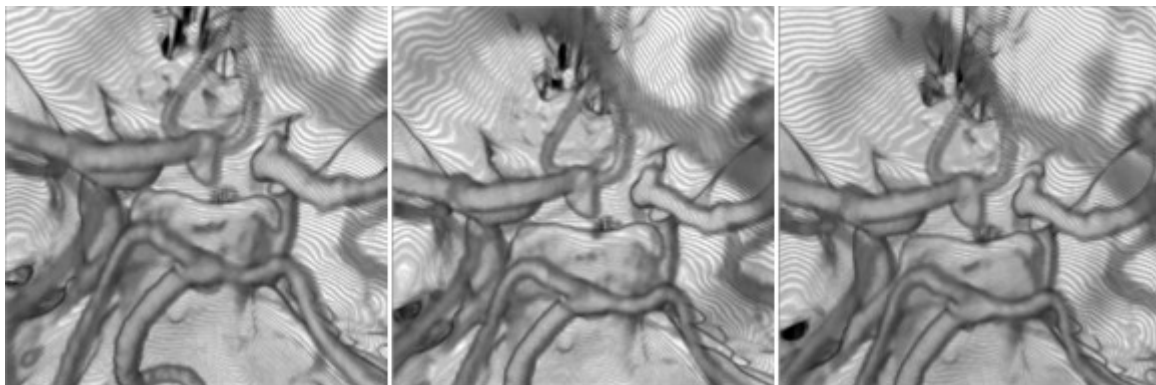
3D volumen rendered images of Acom aneurysm longitudinally followed with CTA at 1 year intervals.
